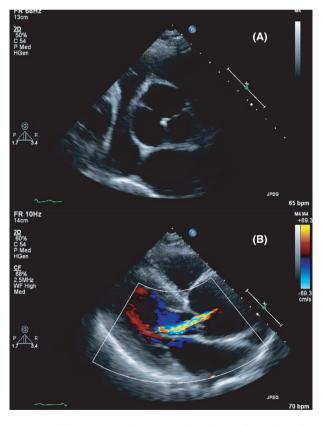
(A) Preoperative transthoracic echocardiography demonstrated a trileaflet aortic valve with a dilated Valsalva sinus and (B) moderate aortic insufficiency.
